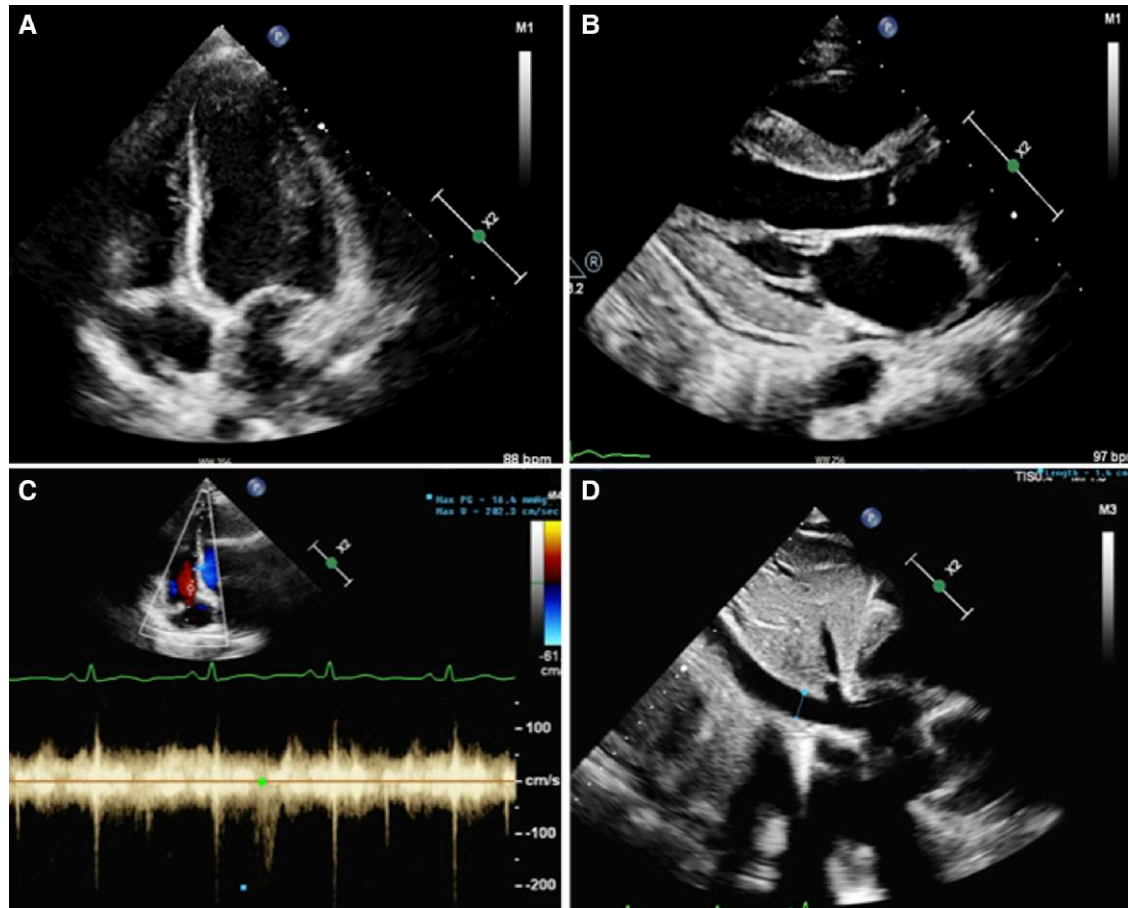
Repeat transthoracic echocardiogram (TTE) 3 weeks post-vitamin C repletion: (A) Apical four chamber view with normal RV size. (B) Parasternal long axis view with normal LV and RV size. (C) Parasternal long axis view with normal tricuspid jet velocity and tricuspid regurgitation pressure gradient of 16 mmHg. (D) Collapsible inferior vena cava measuring 1.4 cm. LV, left ventricle; RV, right ventricle; TTE, transthoracic echocardiogram.
